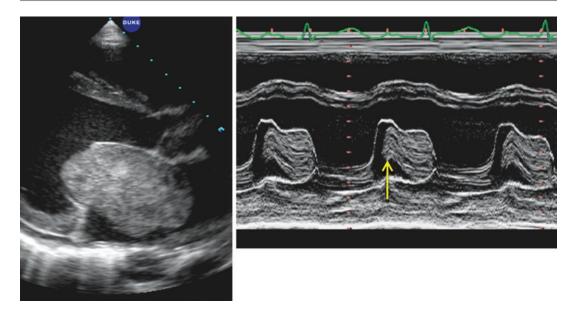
Left panel is a parasternal long axis of the patient seen in the previous figure. The right panel shows a line derived M-mode of the tumor as it moves into place
